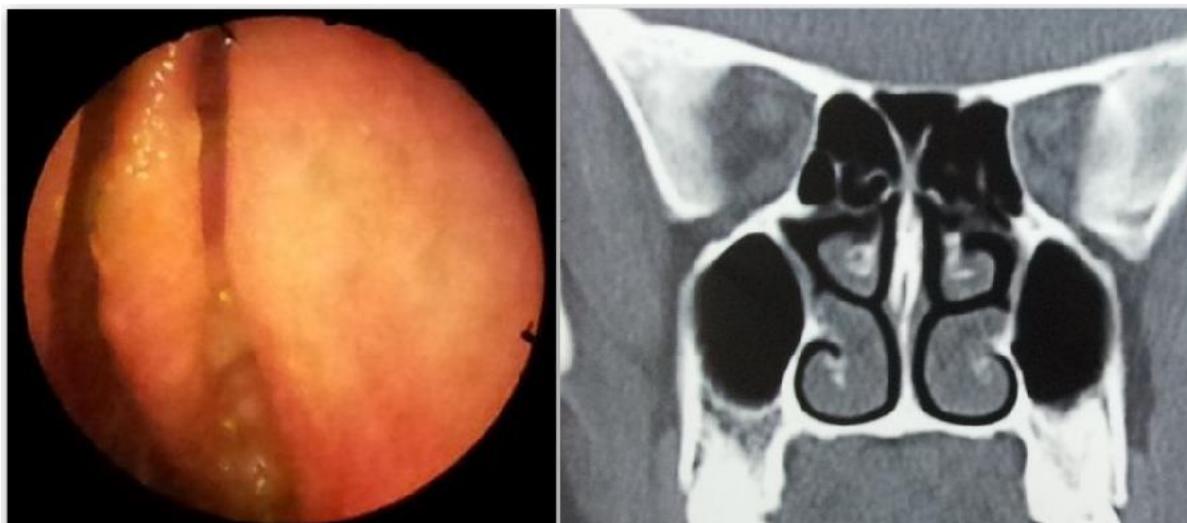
Endoscopic Photograph Showing Early Polypoidal Changes in Middle Turbinate with Mucoïd Discharge, Not Seen on CT Paranasal Sinus (Coronal View).
